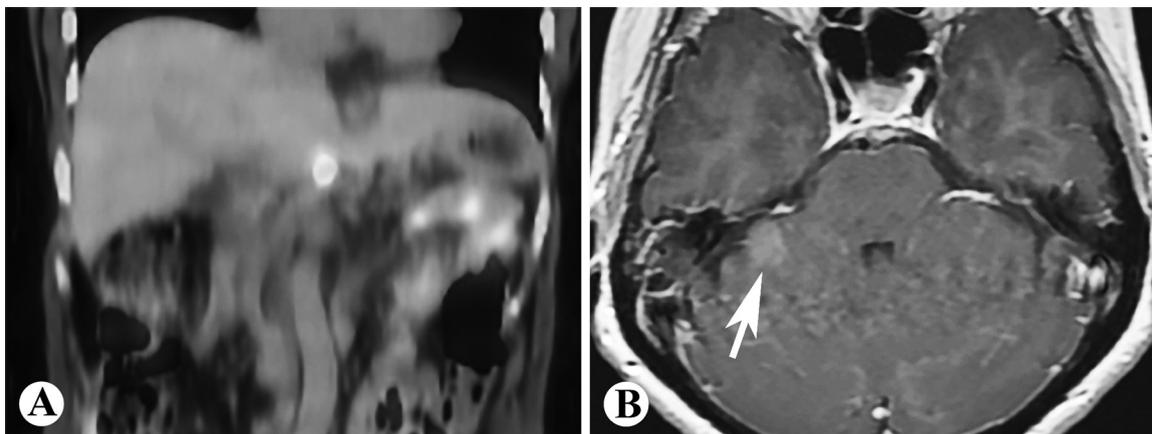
Imaging findings showing the ovarian serous carcinoma metastasis to the liver ligaments and stomach (A, PET/CT, coronal) and cerebellum (B, MRI, axial, arrow).
